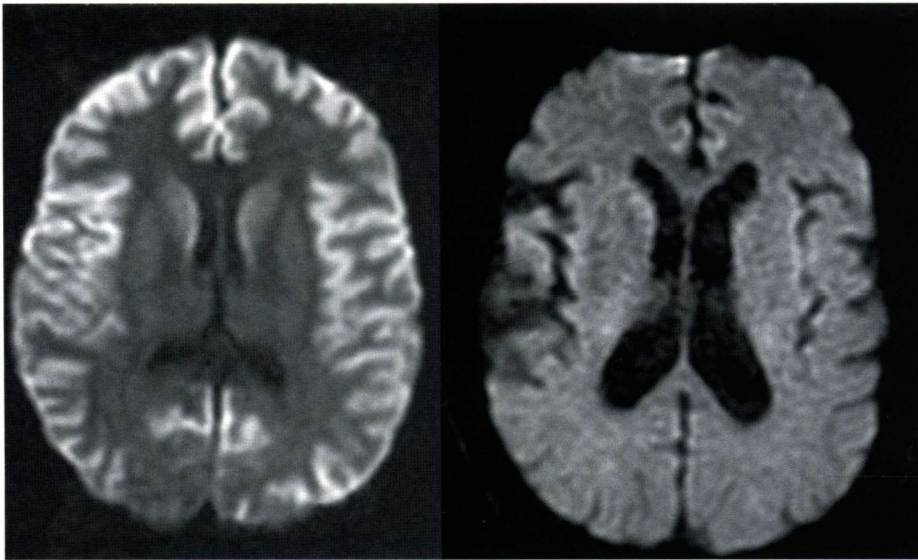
Axial DWI images of a patient with global anoxic injury (left) and of a normal individual (right) highlight the abnormality more clearly.
